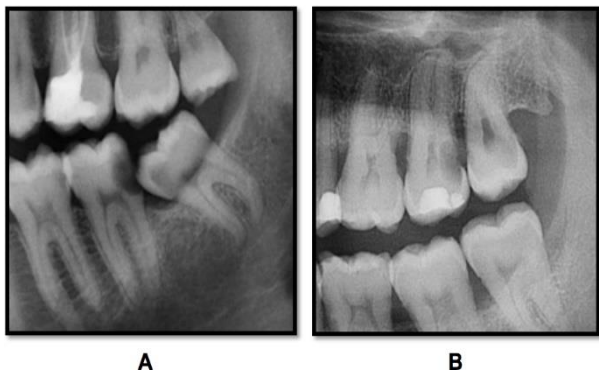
Examples of patients’ panoramic radiographs. (A) A lower third molar with mesioangular angulation and (B) an upper third molar with vertical angulation.
